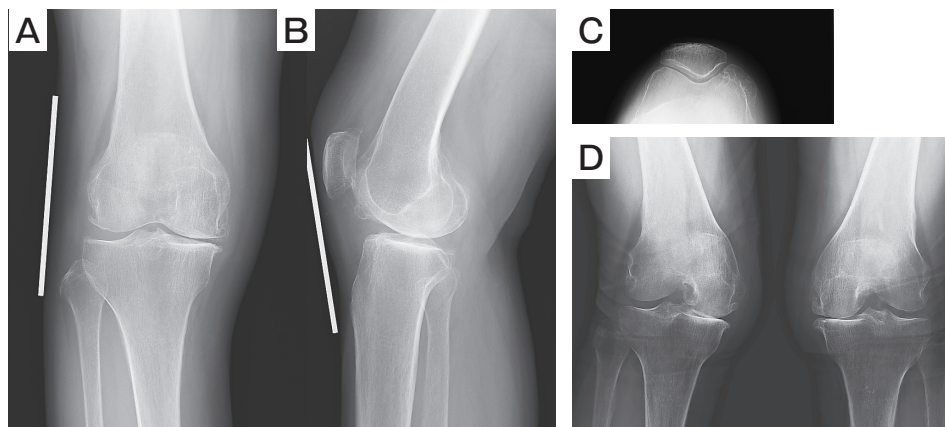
Case 1. Radiograph before operation. A, AP; B, lateral; C, skyline; D, Rosenberg view.
